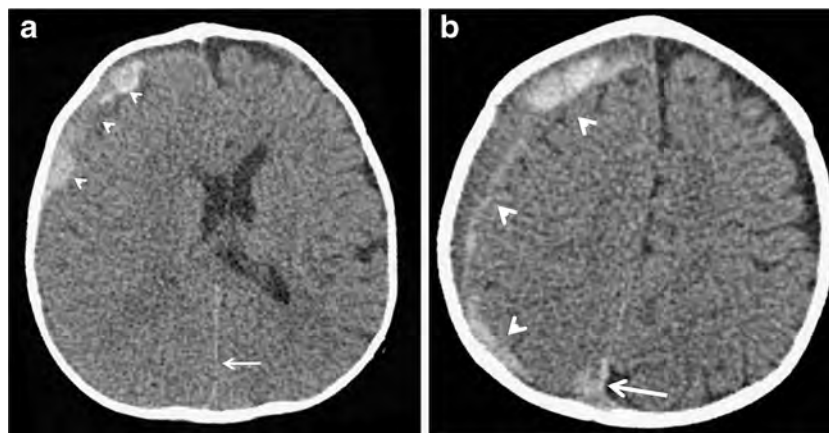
Typical shaken baby syndrome/abusive head trauma. a, b CT of an 8-month-old boy presenting with loss of consciousness, left hemiparesis, seizures and bilateral retinal hemorrhages. Subdural hematoma of heterogeneous density is shown in the right frontotemporal area
